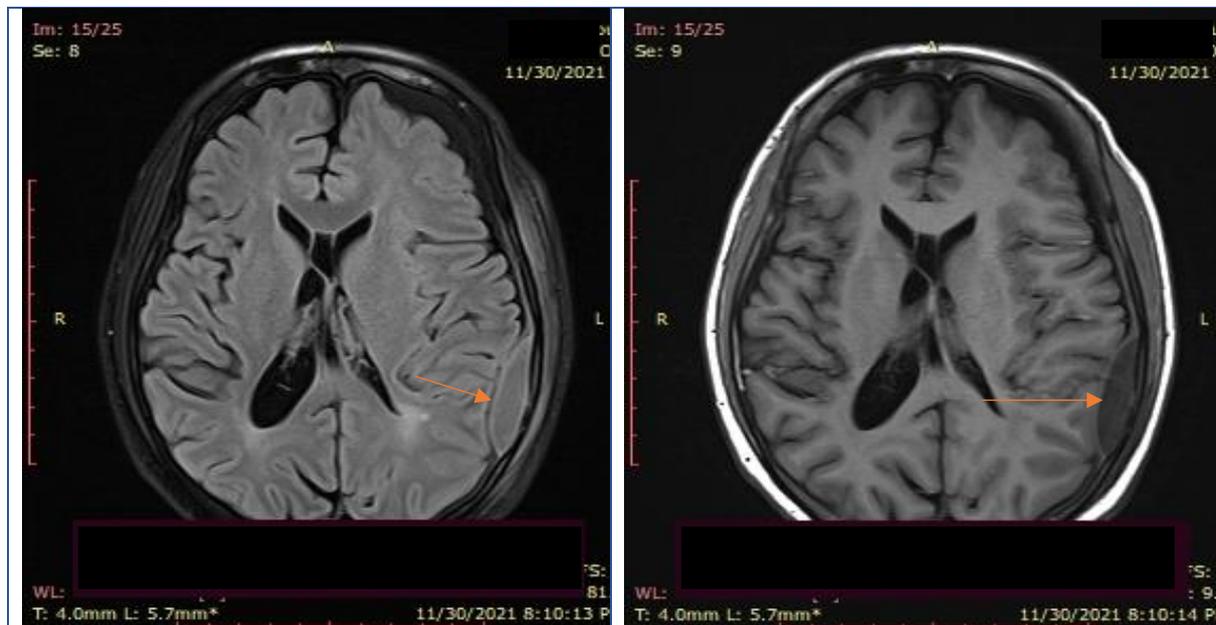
T 1 weighted FLAIR (left) and T 1 weighted (right)
